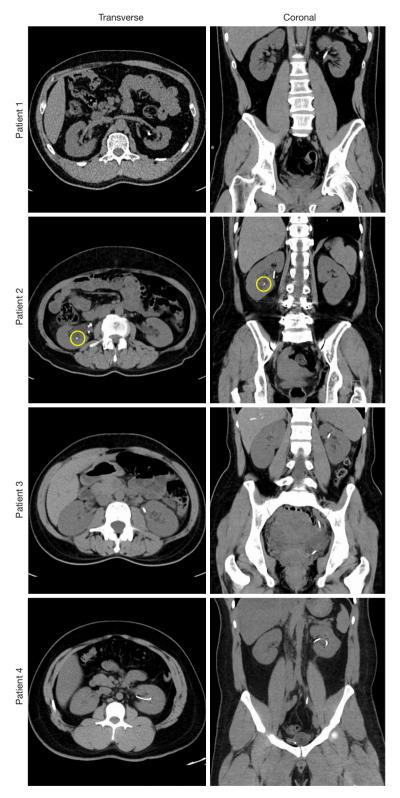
Postoperative computed tomography scans in transverse (left column) and coronal (right column) planes for patients 1 to 4 that have successfully undergone stone removal procedures using the flexible and navigable suction ureteral access sheath. Patient 2 was the only case with residual stones (yellow circles).
